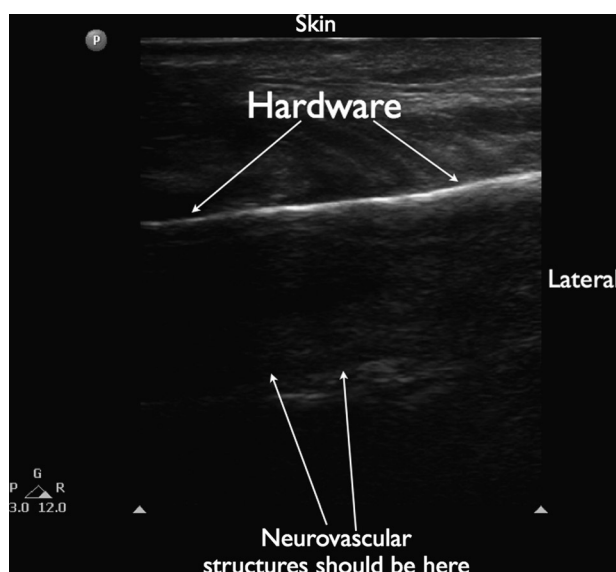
Spinal hardware. This longitudinal parasagittal image of the lumbar sacral spine was generated by placing the transducer in a "paramedian" location. This patient had a previous history of back surgery (laminectomy, decompression, and fusion of L3-5 levels). The ultrasound examination was performed before administration of a spinal anesthetic. The metallic hardware is visualized as hyperechoic lines, with the pedicle screws seen more superficial to the Harrington rods. The ligamentum flavum or the thecal sac is not seen in this view, suggesting possible difficulty in performance of a spinal anesthetic via a paramedian technique. (Image courtesy of Dr. Ki Jinn Chin, Department of Anesthesia, Toronto Western Hospital, University of Toronto, Toronto, Ontario, Canada.)
